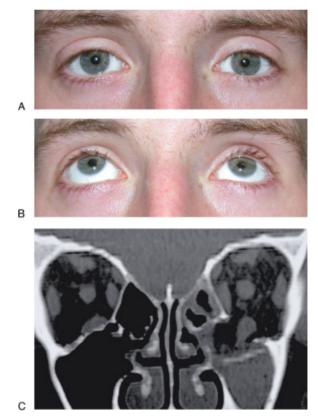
(A) Close-up frontal view of patient with posttraumatic enophthalmos following left-sided orbital floor fracture. Patient had no surgery. (B) Close-up worm's-eye view of same patient as in Fig. 3A with left-sided enophthalmos. (C) Coronal computed tomography scan of same patient as seen in Figs. 3A and 3B performed acutely after fracture showing rounding of the inferior rectus muscle with a height-to-width ratio of greater than 1 (1.38). A significant change in shape can be seen on the involved side as compared with the uninjured side in which the inferior rectus muscle retains its elliptical shape.
